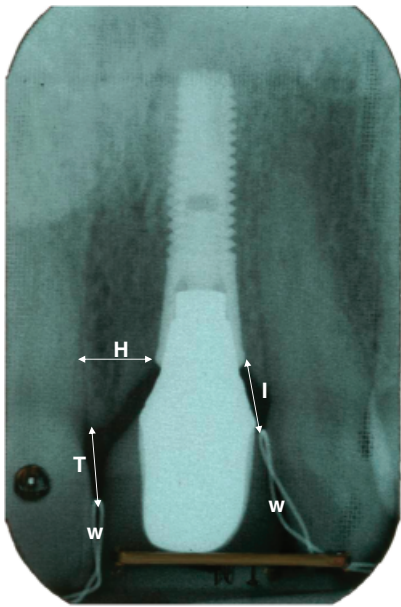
Radiograph of a single-tooth implant replacing a maxillary left central incisor showing the wire (W) encircling contact point. The arrow on the mesial aspect depicts a measurement from the wire to the tooth associated bone crest (T). The arrow on the distal aspect depicts a measurement to the bone level on the implant (I). The horizontal arrow (H) depicts a measure from the shoulder of the implant to the adjacent tooth.
